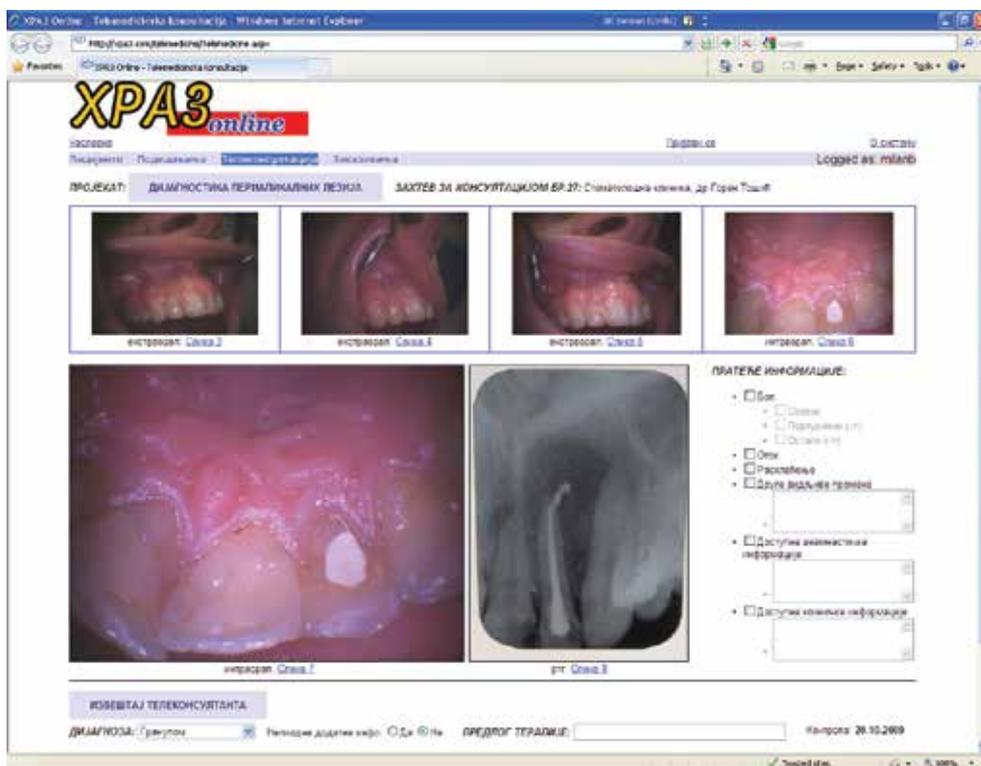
Telemedical online server XPA3 Online, Serbia, distant help in cases of periapical lesions
